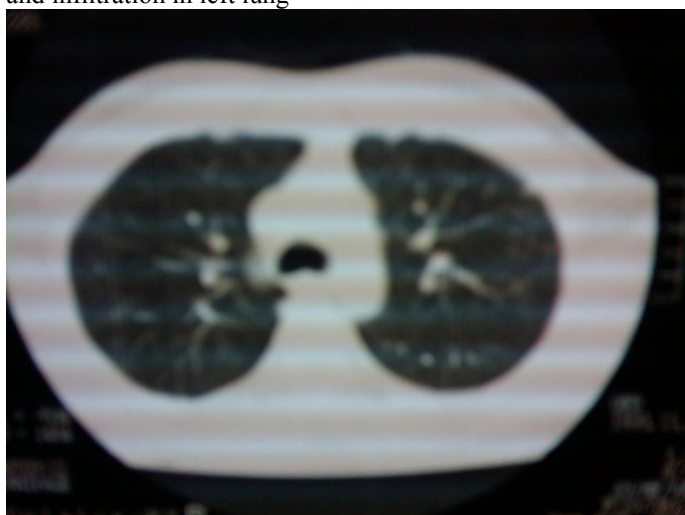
Chest CT-scan is normal after 4th cycle of ABVD.
